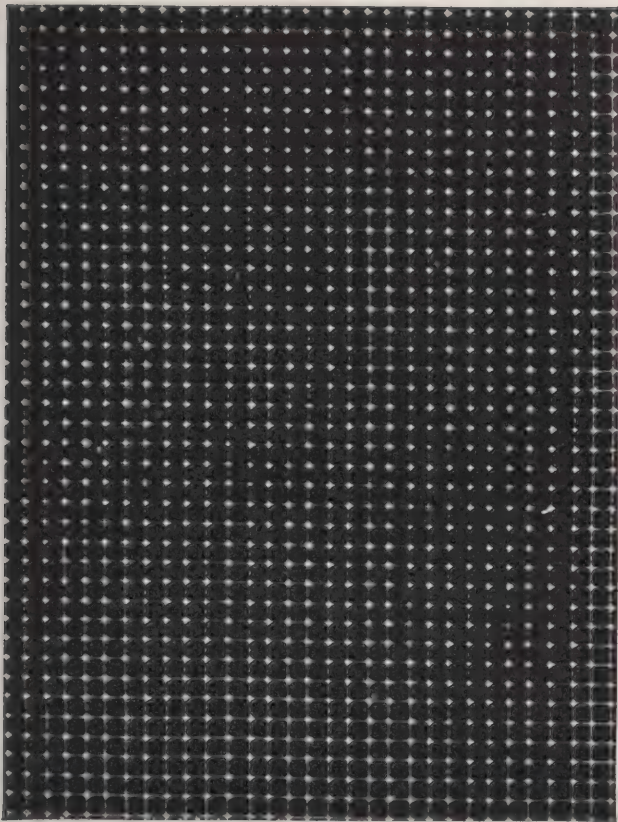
Testing for screen contact. (a). Roentgenogram of wire screen showing good intensifying screen contact. (b). Poor intensifying screen contact.
